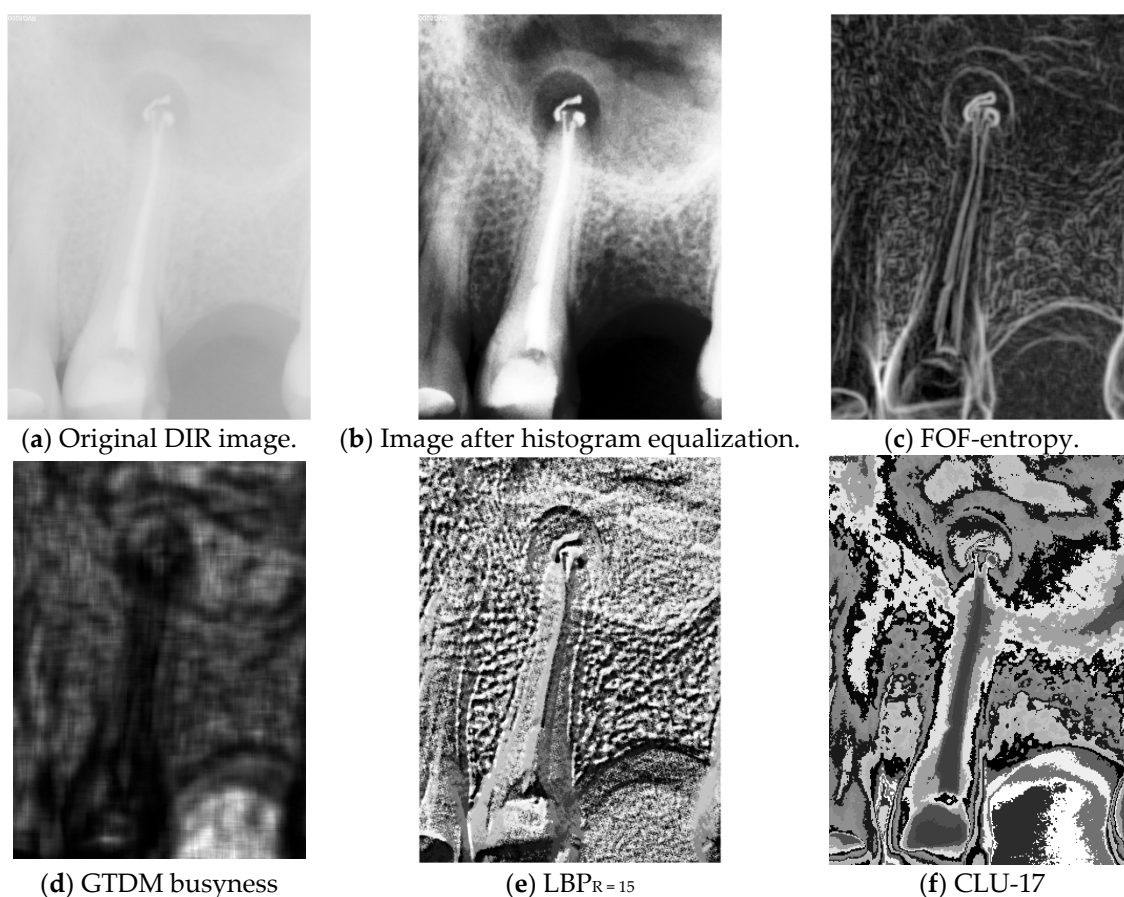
Various aspects of image preprocessing. (a) Original data. (b) The same image after histogram equalization shows improved contrast but does not depict the structure clearly in the tooth region. (c–f) Examples of feature maps derived from a digital intraoral radiographic image via various texture analysis methods. CLU, clustering with k-means approach; DIR, digital intraoral radiography; FOF, first-order features; GTDM, gray-tone difference matrices; LBP, local binary patterns.
